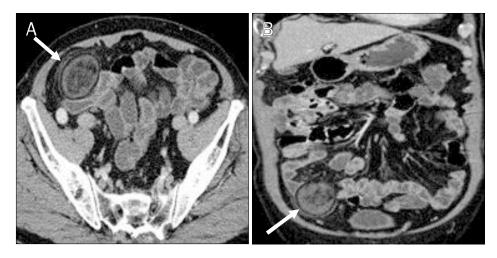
Computed tomography findings. (A) A well-defined heterogenous fatty mass measuring 4.5×3.5 cm in size suggesting fat necrosis (arrow: mass, transverse section). (B) Right hemicolectomy state with right lower abdominal fatty mass (arrow: mass, coronal section).
